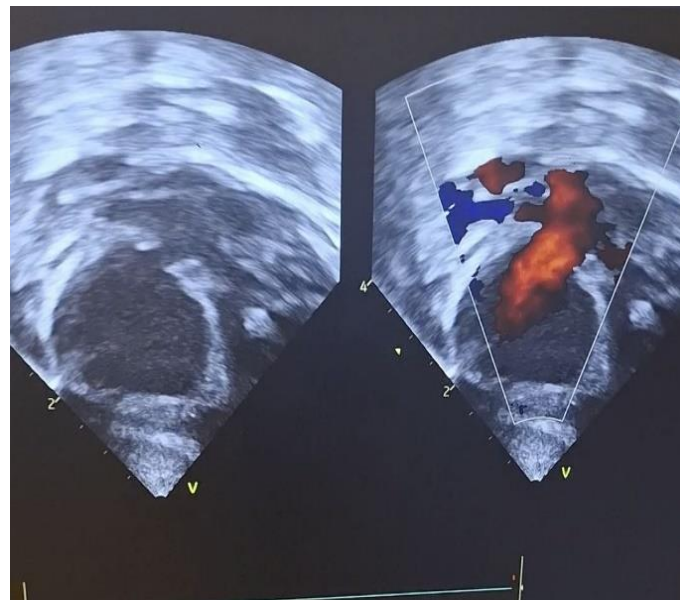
Echocardiogram with Doppler ASD II
